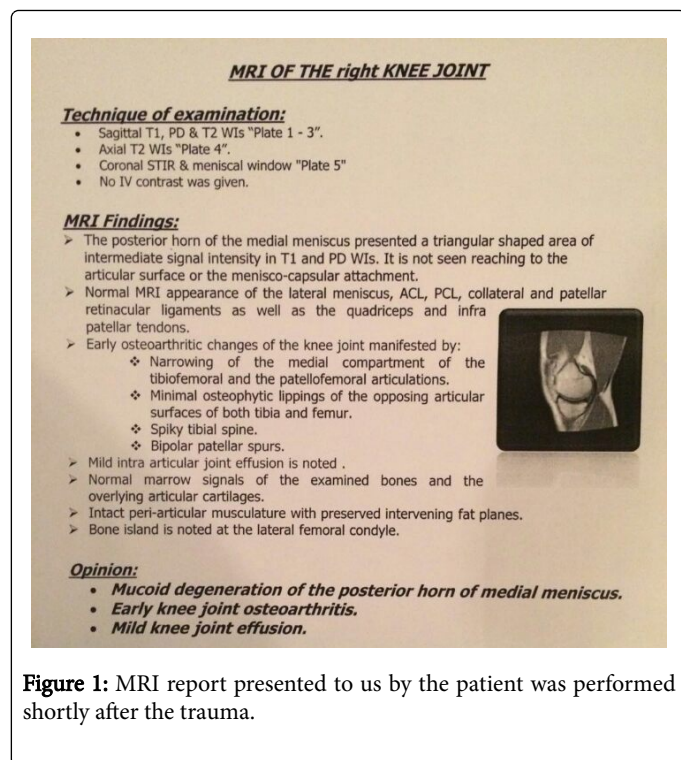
MRI report presented to us by the patient was performed shortly after the trauma.
